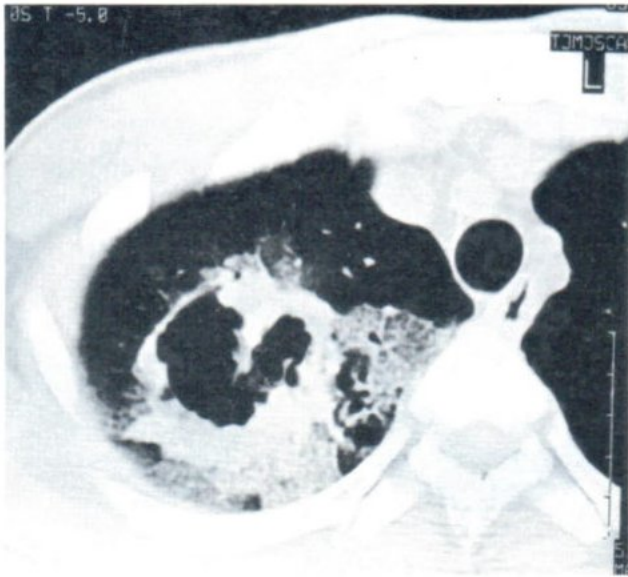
Bronchogenic carcinoma, non-small cell type. HRCT chest of a 33-year-old man, who presented with chronic cough and blood-tinged sputum, revealed the crazy-paving pattern at the posterior segment of RUL with a nearby large cavity showing thick irregular wall and internal septation. Transbronchial biopsy showed bronchogenic carcinoma, non-small cell type.
